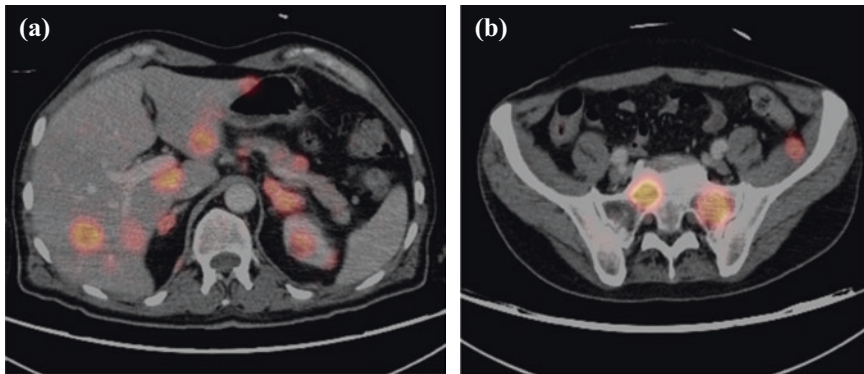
A 53 year old man with a history of malignant melanoma and recent weight loss presented for a PET—CT scan to assess for recurrence. There is evidence of disseminated malignancy with multiple FDG avid areas including multiple hepatic, renal and adrenal metastases (a). Multiple intramuscular and osseous metastases are also present (b)
